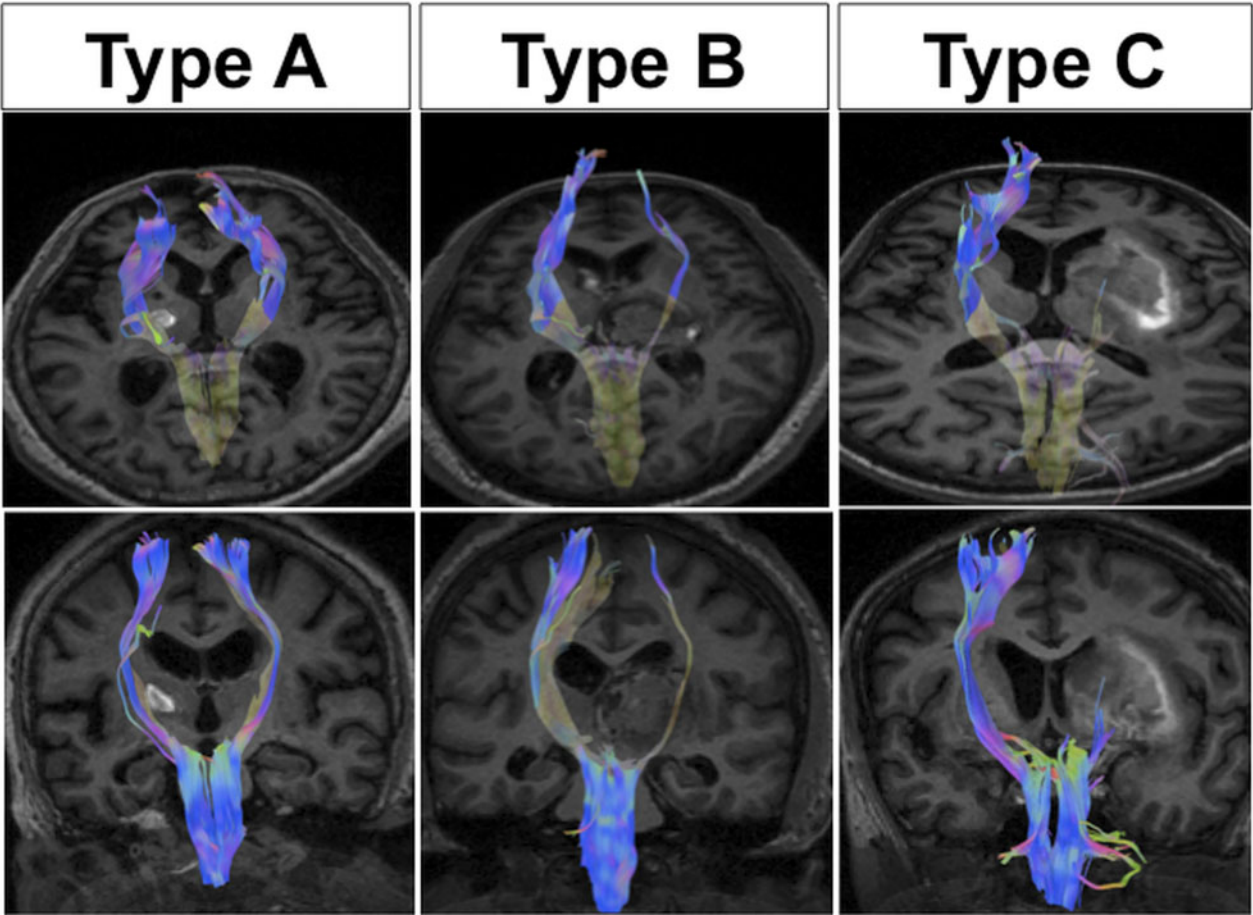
Classification of diffusion tensor tractography (DTT) for an injured corticospinal tract (CST). T1-weighted brain MR images, axial images and coronal images of DTT at the cortex level (showing the integrity of DTT). Type A, the CST originating from the cerebral cortex was preserved around the haematoma; type B, the CST was partially interrupted; type C, the CST was completely interrupted around the haematoma.
